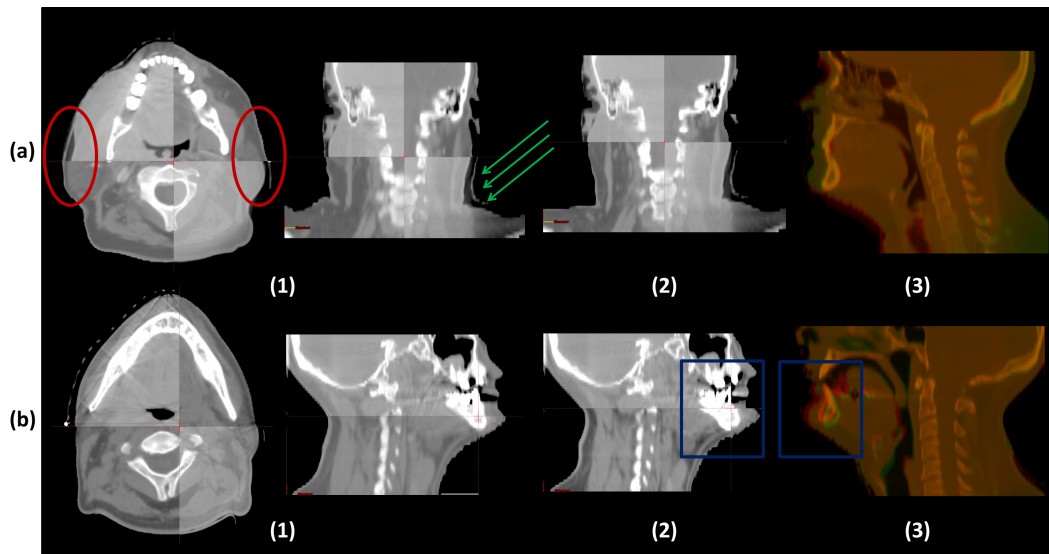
Checkerboard rendering for patient 6a and 7 virtualCT and CBCT after deformable registration are presented in panels (a.1) and (b.1) respectively, while panels (a.2) and (b.2) shows the comparison between CTrepl and CBCT after rigid correction. In the image overlay (a.3, b.3), red codes for CBCT and green for rigidly registered CTrepl. Note the effect of a sub-optimal masking of CBCT in the red circles in panel (a.1): we clearly see how the deformable registration does not detect the mask (green arrows) as external structure, because the immobilization is in the same HU of patient tissue. For patient 7, we could not use the proposed validation method, because of the different jaw position in CTrepl and CBCT (blue squares).
